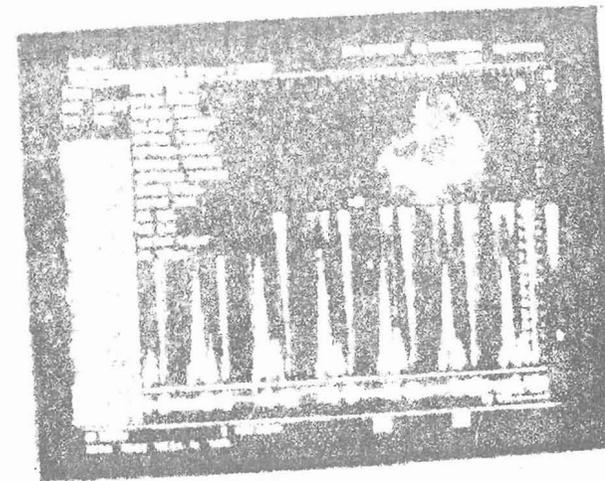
Colour Flow Doppler Showing Severe Mitral Regurgitation
